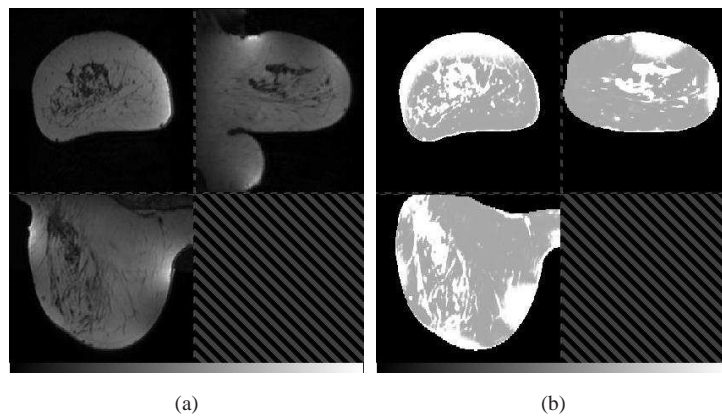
(a) Pre-contrast MRI with strong bias field and (b) the X-ray attenuation volume. The inhomogeneity correction was not successful for this case.
